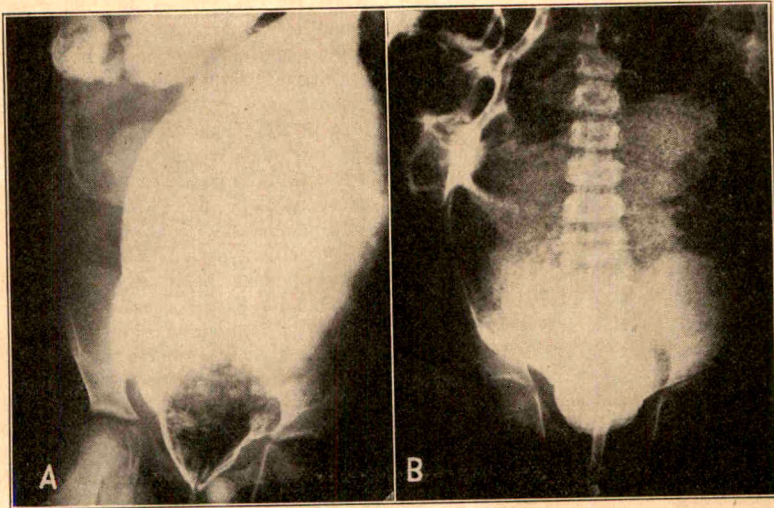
(case 20).—*A*, roentgenogram showing the distended and impacted megacolon in a 6 year old boy. The major involvement is in the descending and sigmoid colon and the rectum. Rectal manipulation and medical treatment had been employed for four days. *B*, roentgenogram taken twenty days later; medical treatment has partly broken up the impaction but has not relieved the distention due to gas. This patient, with enormous involvement of the lower part of the colon and rectum, is living, without surgical intervention and with only moderate difficulty, five years later.
